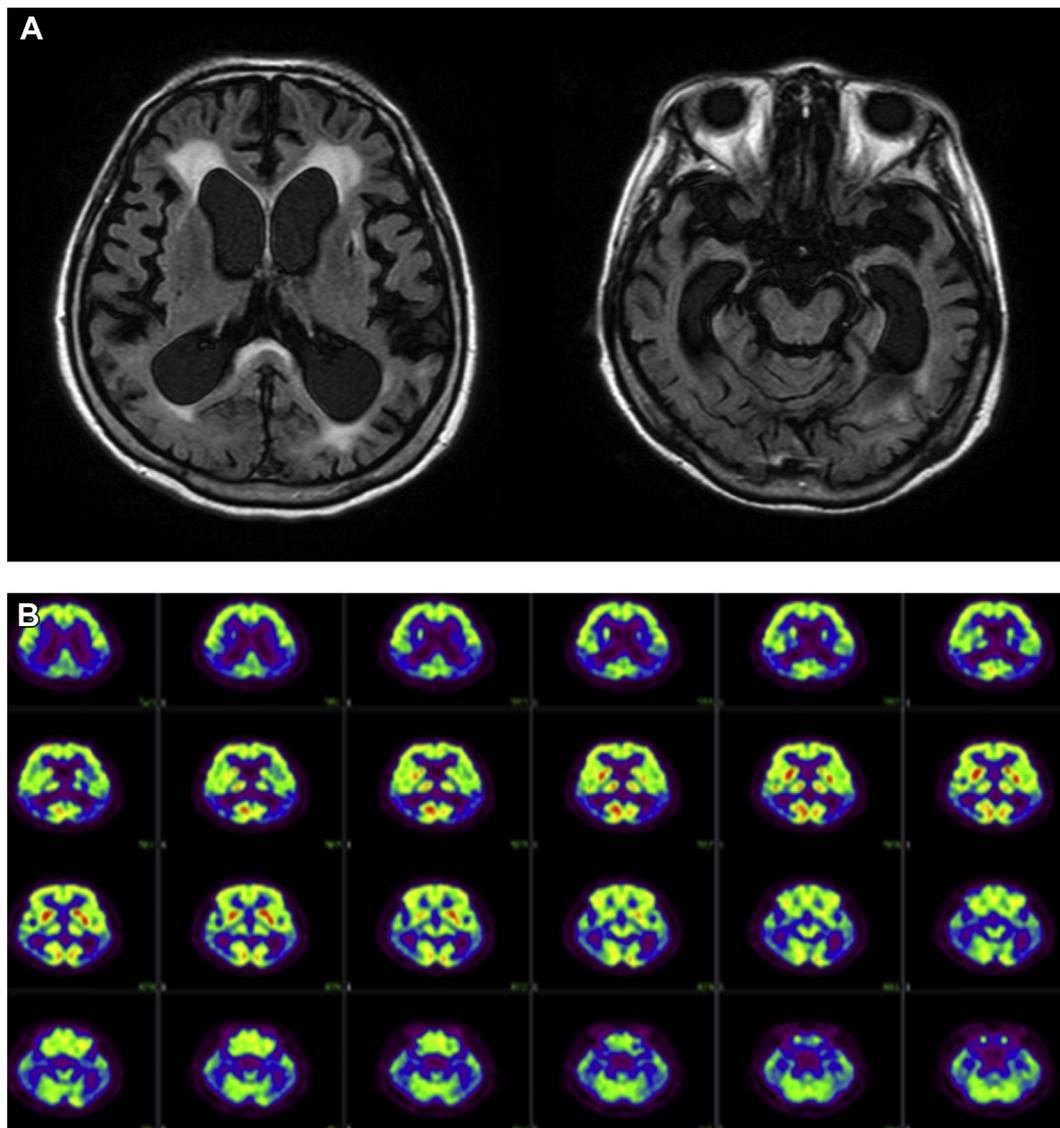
(A). MRI revealed pronounced hippocampal atrophy and (B). FDG-PET showed bilateral and temporoparietal hypometabolism. Abbreviations: FDG-PET, ^{18}F -fluorodeoxyglucose positron emission tomography.
